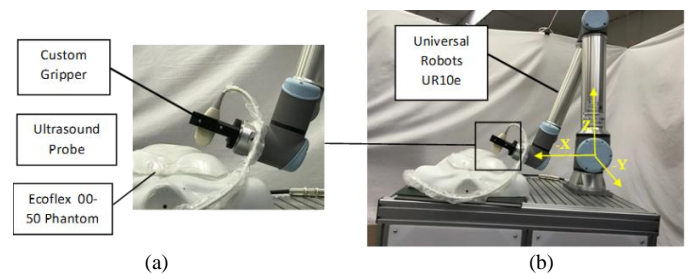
(a) Hardware setup of ultrasound scanning (b) Hardware setup of the experiment with a coordinate system.
